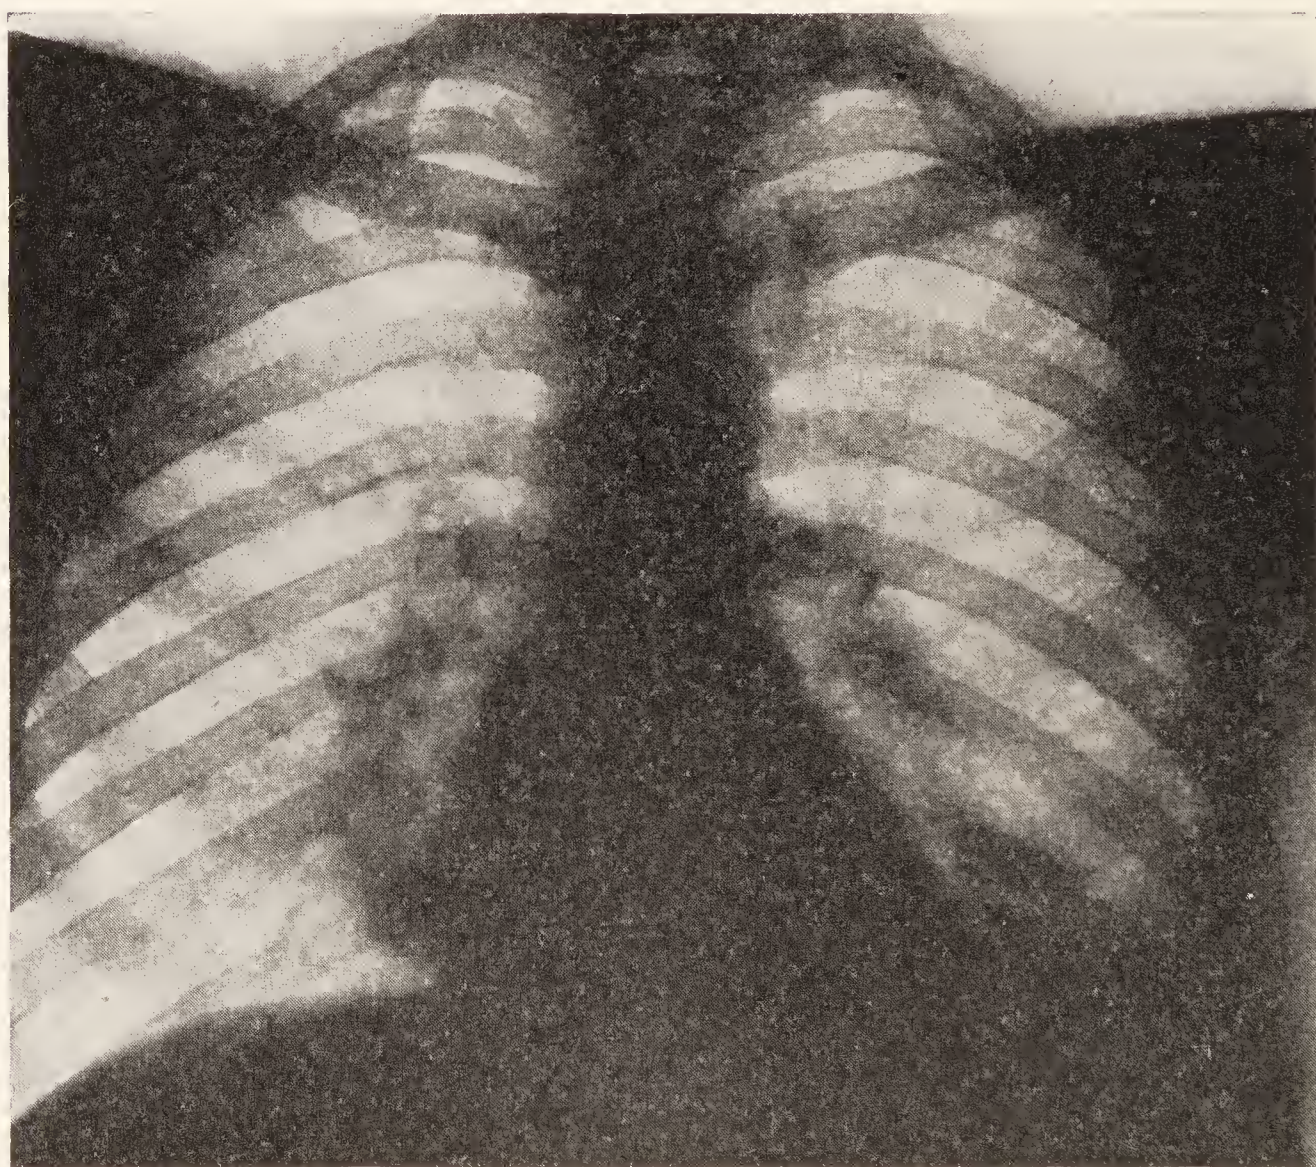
Chest in July, eleven months after first admission, after X-ray treatment. Looks practically clear except for an area of somewhat increased density at the right base close to the heart border. Diaphragm on the left apparently high. Left costovertebral angle hazy.
